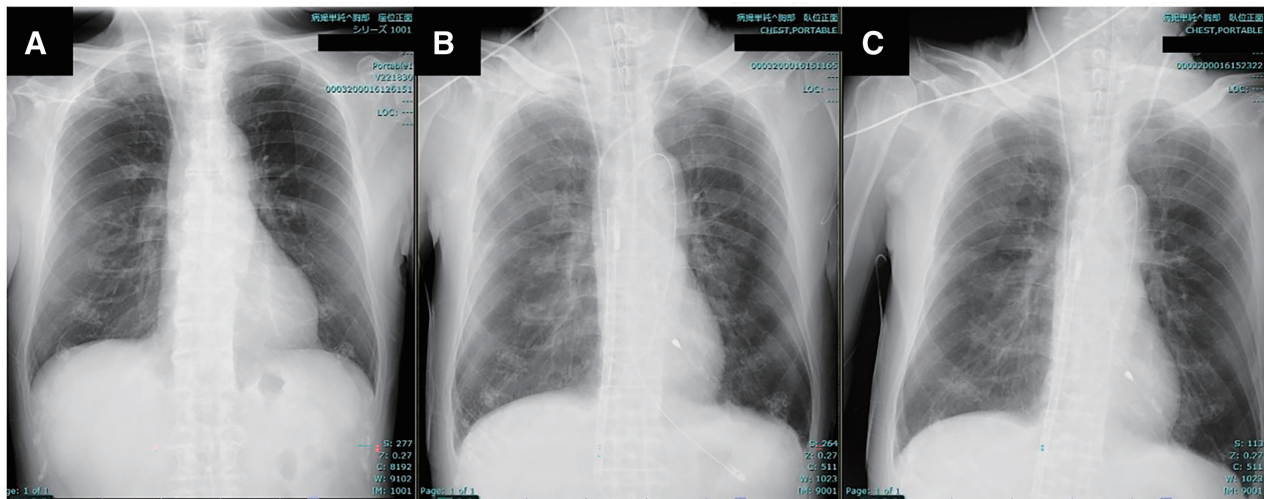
A comprehensive evaluation of the X-ray findings revealed a significant improvement in the patient's pulmonary edema. (A) Preoperative. (B) Immediately after surgery. (C) Postoperative day 1.
